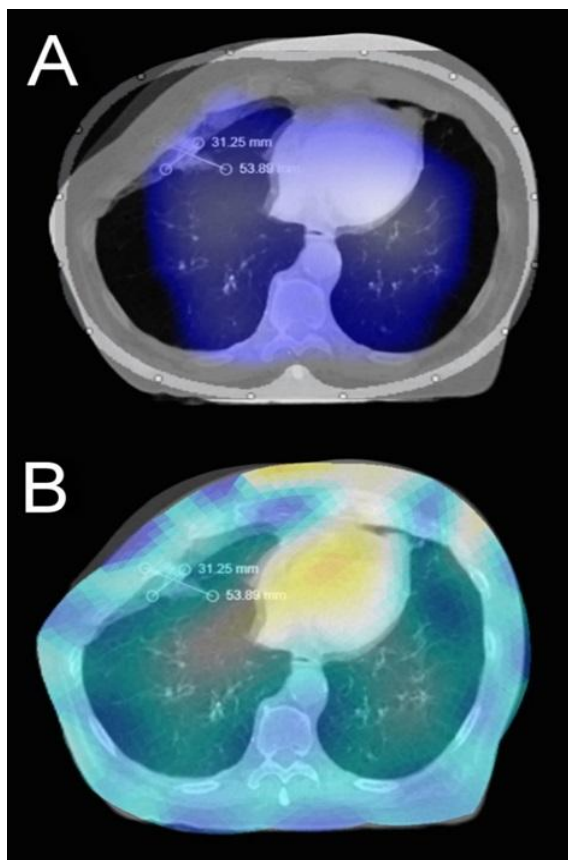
Comparison of spatial conformity between a standard EIT image/CT scan and a personalized EIT image/CT scan of patient 2
